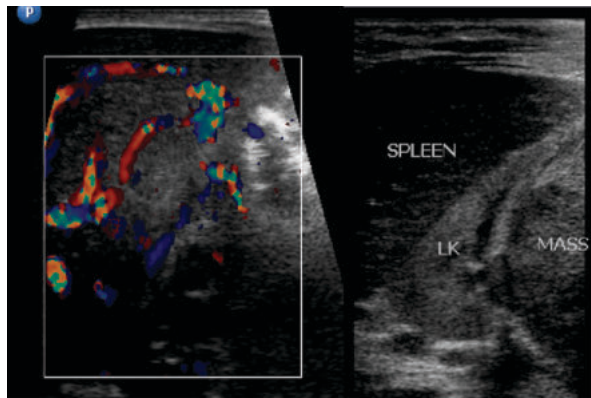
Malignant rhabdoid tumour of the kidney – A large solid vascular hypoechoic mass is seen arising from the lower pole of the left kidney (LK). Preserved upper pole parenchyma is seen in the second image. Ultrasound features of Wilms', CCSK, and Malignant rhabdoid tumors are similar and they are indistinguishable many times.
